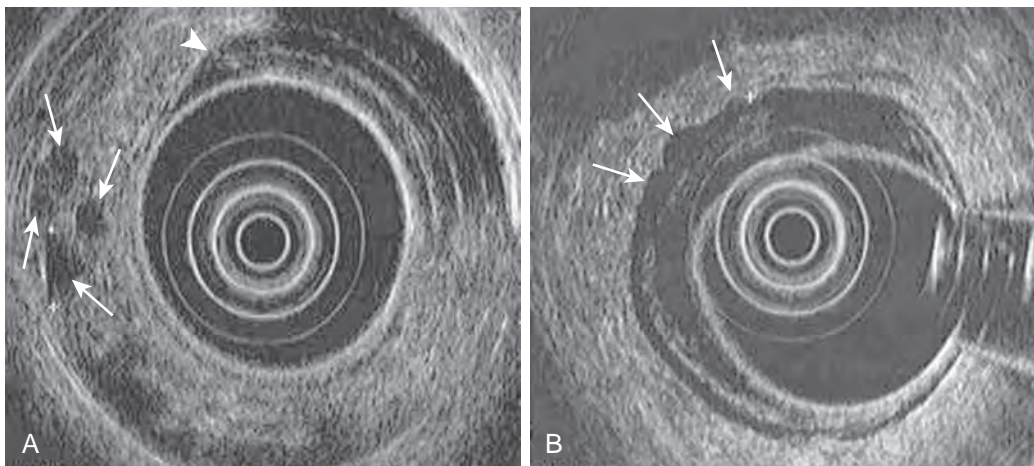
Transrectal ultrasound of rectal tumor (T3N1). A. TRUS image shows several lymph nodes in perirectal fat (arrows) and marked thickening (arrowhead) of rectal wall. B. TRUS image demonstrates thickened anterolateral wall of rectum as a low echogenicity structure with nodular outer margin (arrows) against the surrounding high signal intensity fat. This indicates transmurum tumor extension (T3).
